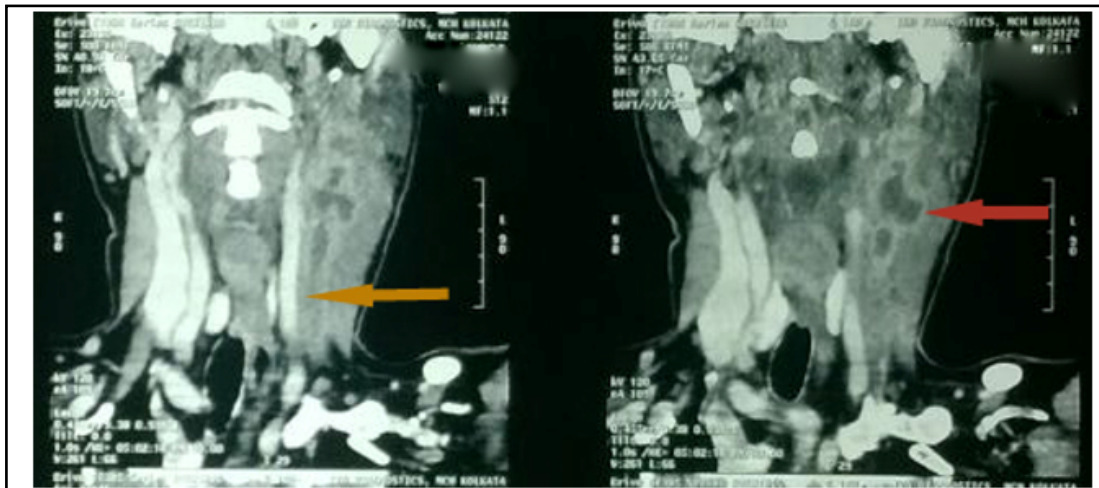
CT scan of neck. Yellow arrow points to the thrombosed left internal jugular vein. Red arrow points to adjoining left sided level 2 and 3 suppurative cervical lymphadenopathy with central necrosis
